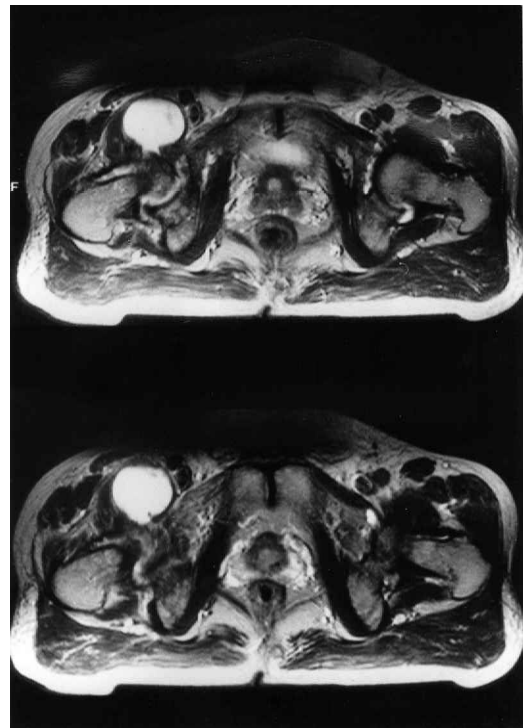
Abnormal signal intensities (T2-weighted axial images) of right femoral head, revealing typical avascular necrosis with an enlarged iliopsoas bursa just anterior to the right femoral head, which communicates with the joint.
